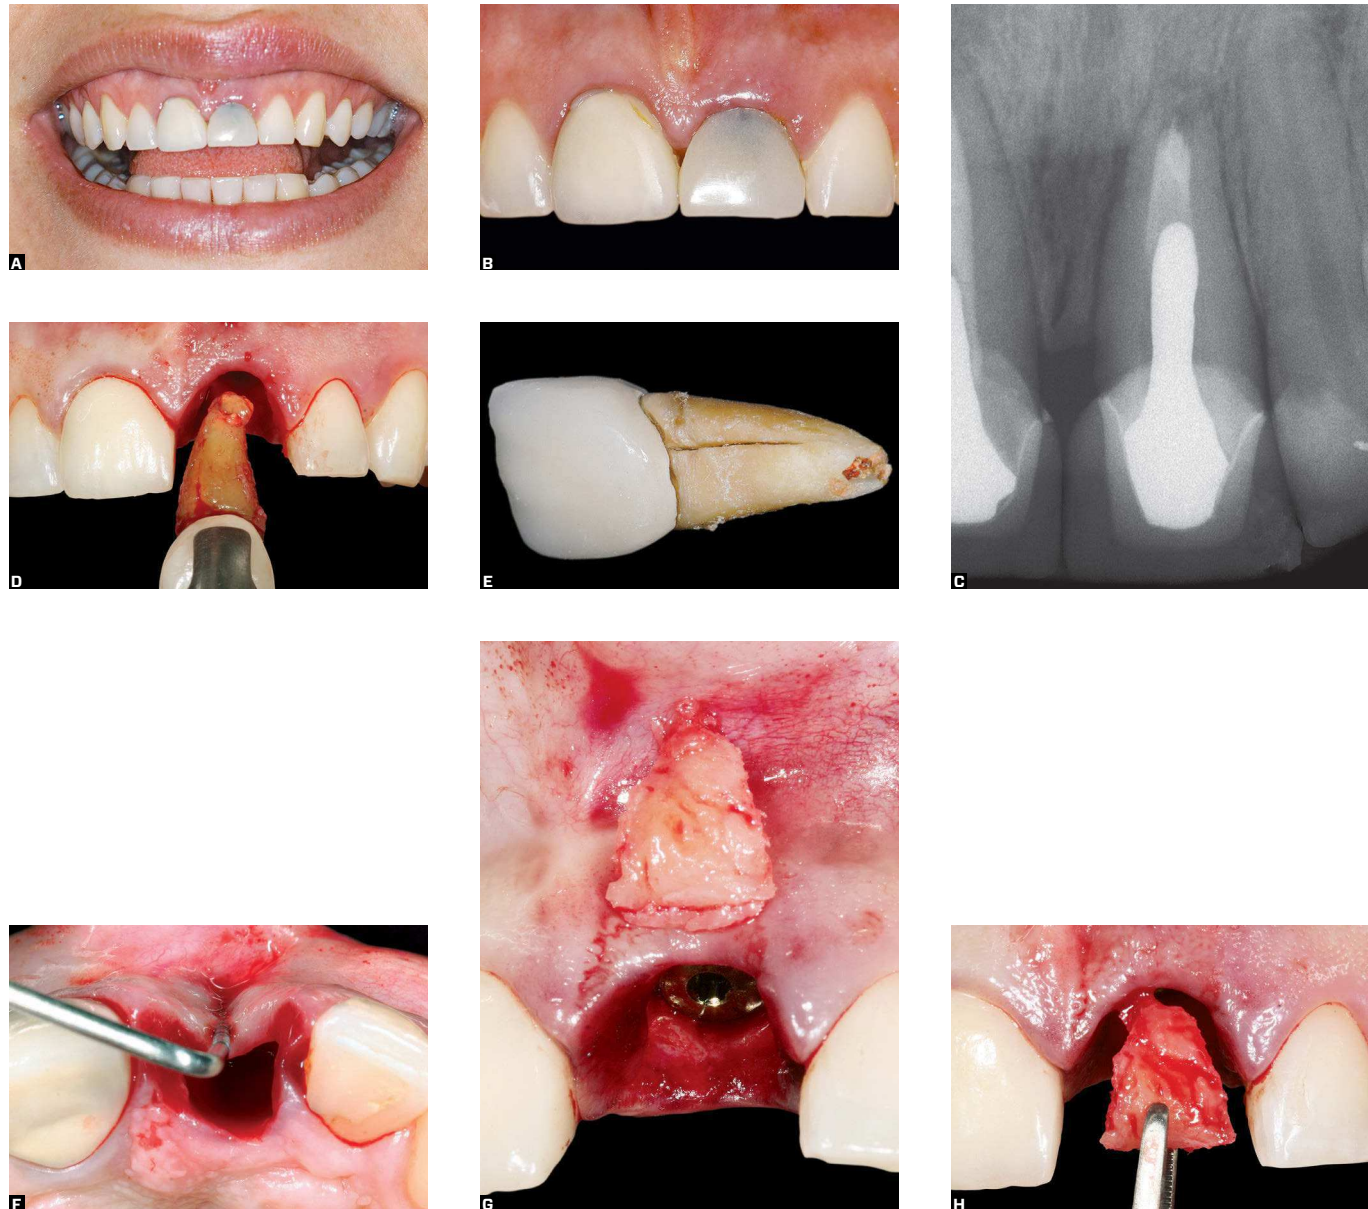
A) View of gingival smile, which poses difficulties to achieving good esthetic results. Clinical probing (tooth 21) revealed root fracture. B) Figure B shows inflammation of marginal gingiva. Patient reported recurring release of crown and cast metal post. C) Radiograph of tooth 21 shows discrete apical lesion. D) Surgical stage of extraction: at this stage, the purpose is to limit trauma to surrounding tissues to a minimum. E) Extracted tooth, with longitudinal root fracture. F) Compression of gingiva and loss of buccal bone plate. G, H) Bone fragment in form of wedge removed from maxillary tuberosity during dimensional checking before grafting.
